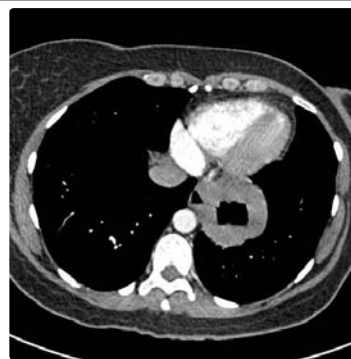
CT chest showing a large hiatus hernia and the tumour
